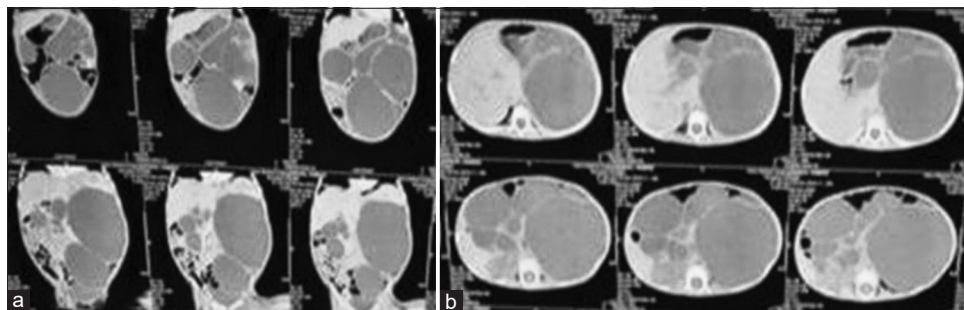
(a and b) Computed tomography scan of the child showing multiple abdominal cysts.
